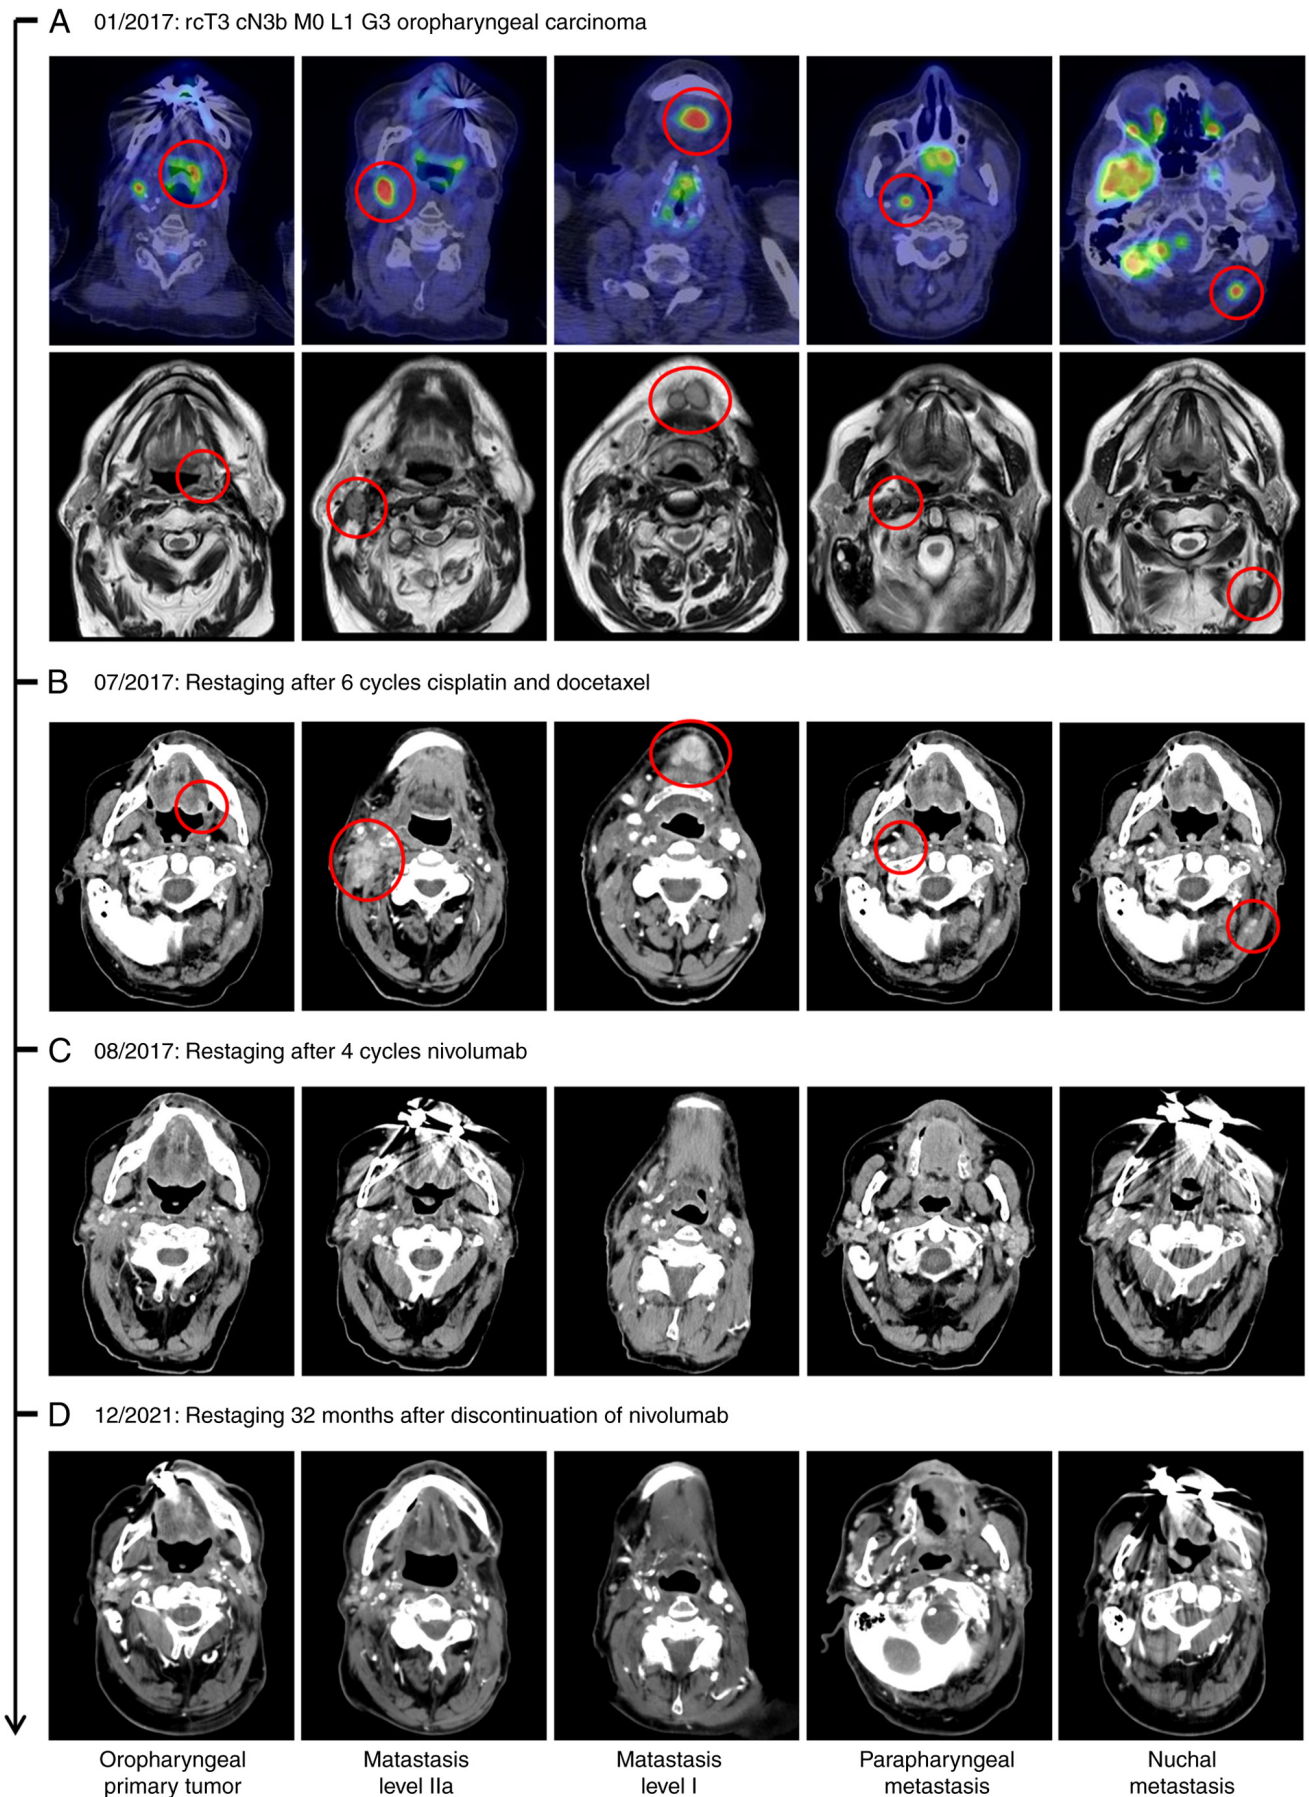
Radiological assessments. (A) FDG-PET-CT and MRI shows a primary tumor of the oropharynx with bilateral neck masses as indicated by red circles. (B) Progressive disease detected on CT scan of the neck following 6 cycles cisplatin and docetaxel as indicated by red circles. (C) Therapy was switched to nivolumab and CR was achieved after 4 cycles. (D) The patient received 42 overall cycles of nivolumab. Even after 32 months after discontinuation the patient remained under CR. CT, computed tomography; FDG-PET, 18-Fluoro-deoxyglucose positron emission tomography; CR, complete remission.
